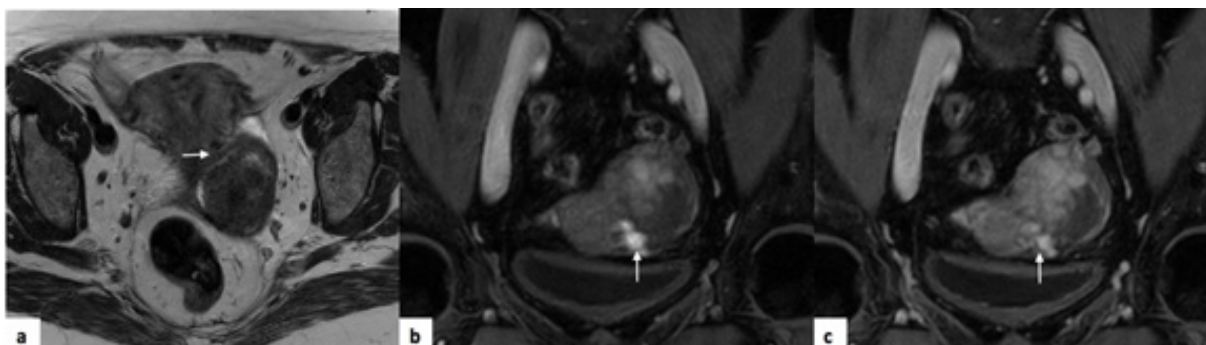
Subserosal uterine leiomyoma. Pelvic MRI of a 64-year-old woman. (a) Axial T2-weighted image, where it is possible to detect a signal void corresponding to of vascular structures between the lesion and the uterus (bridging vessel sign) - arrow. These vascular structures are best visualised on coronal T1-weighted images with fat saturation after intravenous contrast (b) and (c) - arrows.
